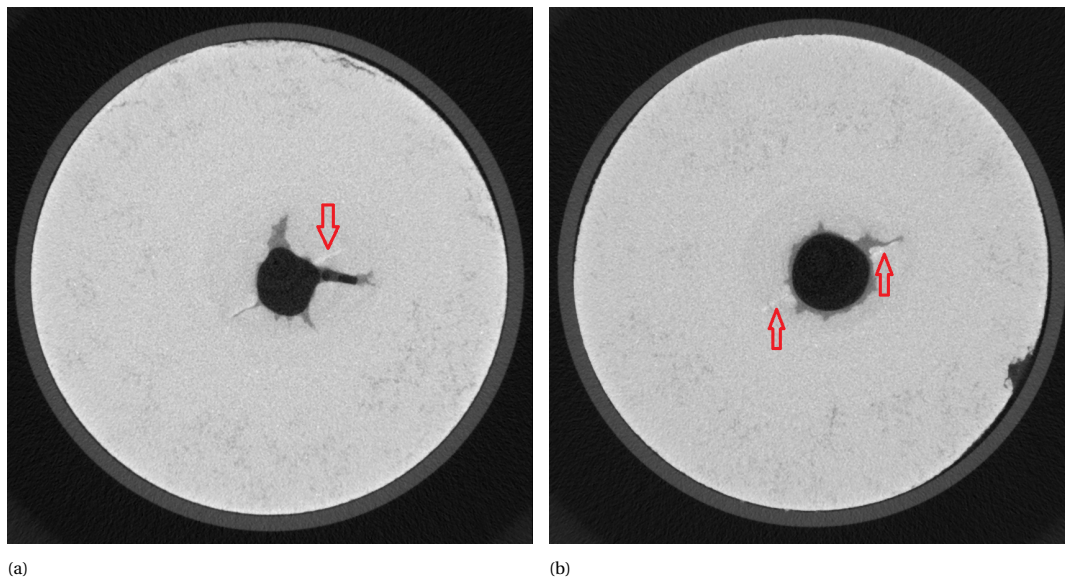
Experiment 1 - Micro CT fracture photos
